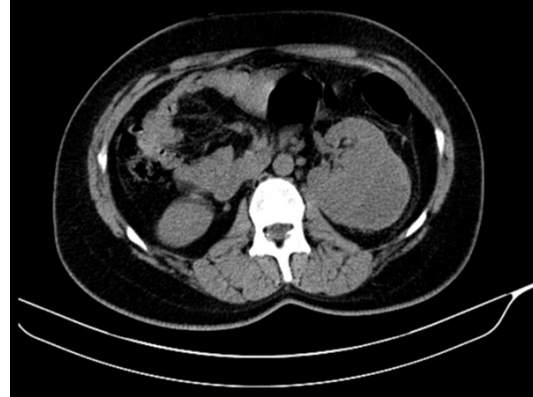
Axial Abdominopelvic CT scans without contrast confirm the decreased change in hematoma size after four weeks.
